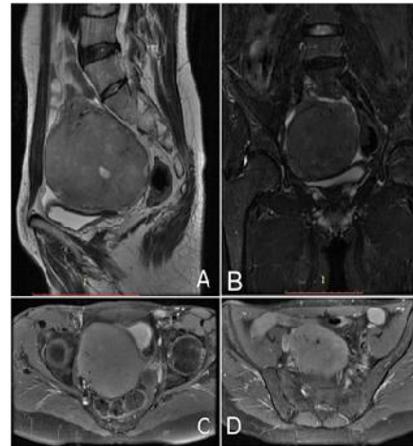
A and B - Sagittal and coronal T2W MRI scan of the abdomen and pelvis shows a tumor mass with a hypointense zone that corresponds to fibrous tissue; in the upper region there is a liquid capsule rich in flow voids that appear to be blood vessels. C and D - Axial T2W MRI scan shows a high uptake mass in the left iliac region, posterior to the psoas muscle.
